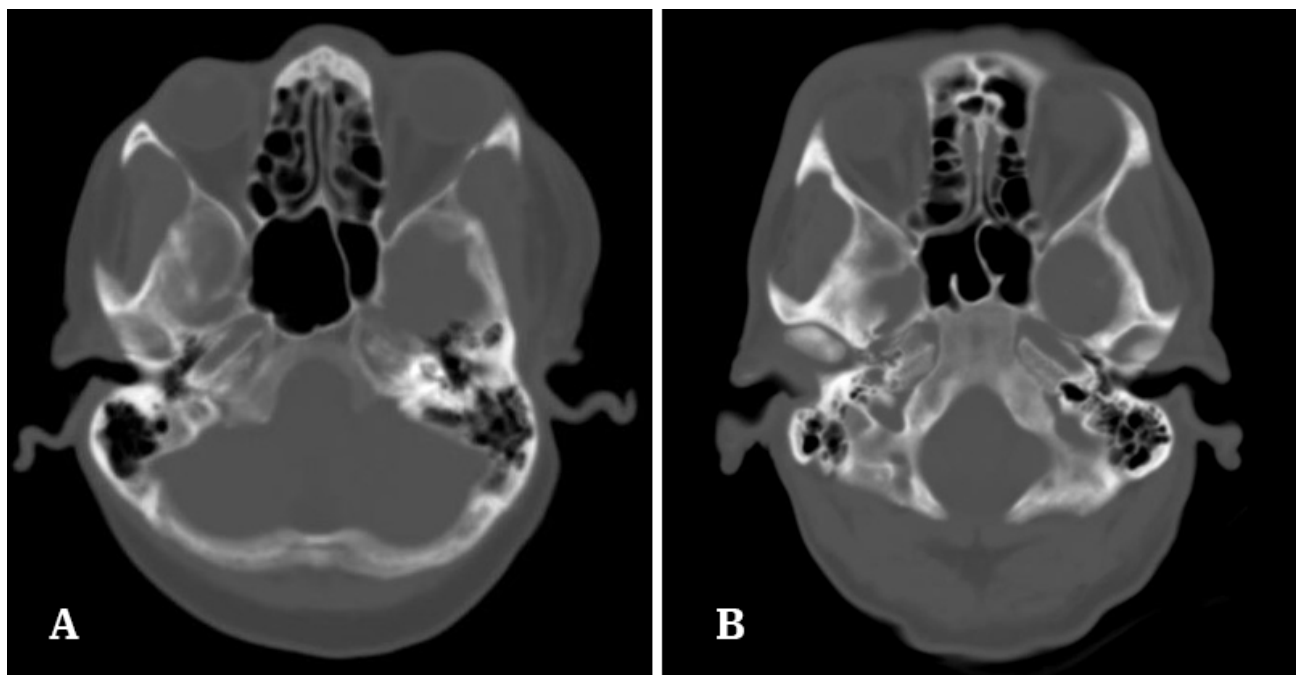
Axial CT images depicting the SS septa. A: single complete septum located paramedian B: Single complete septum with partial septa projecting in the sphenoid sinus bilaterally.
